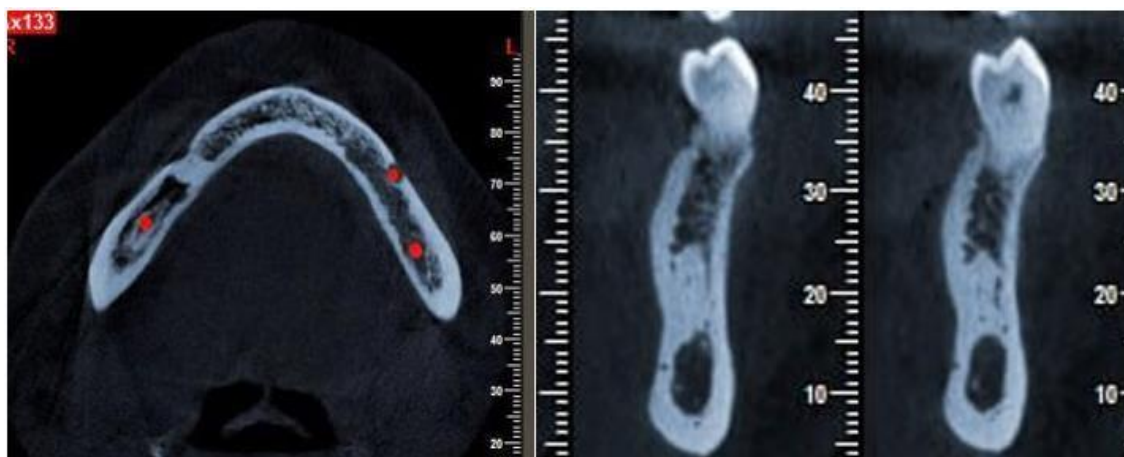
Axial and cross-sectional views of CBCT of IO in the mandible in close contact with both cortical plates.
